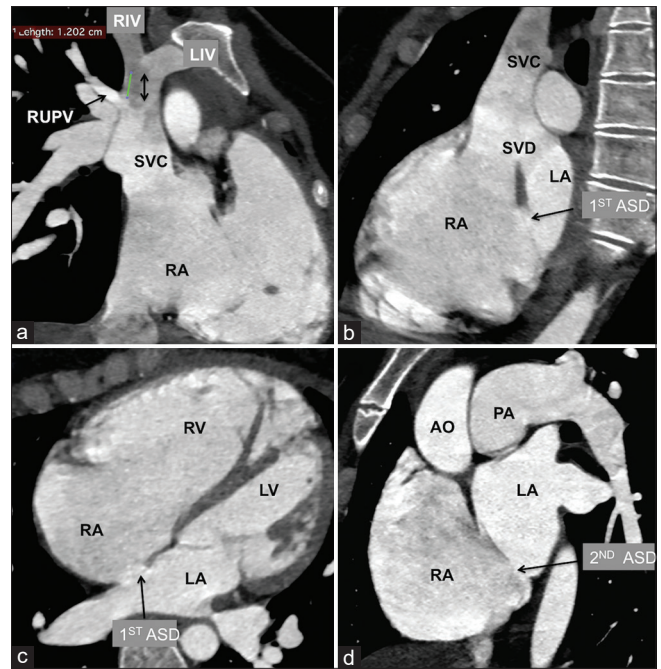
Computed tomographic modified coronal (a), sagittal (b), axial (c), and oblique (d) images demonstrate superior vena cava straddling of the sinus venous defect. The anchoring zone between the union of the right innominate veins and left innominate veins and the drainage of the right upper pulmonary vein is short, measuring 1.2 cm (double arrow). The right atrial and right ventricular dilation compared to the left atrium and left ventricle are additionally contributed by shunt through two atrial septal defects, one located in the middle of the oval fossa and other inferiorly. RUPV: Right upper pulmonary vein, LV: Left ventricle, RV: Right ventricle, LA: Left atrium, RA: Right atrium, SVC: Superior vena cava, LIV: Left innominate vein, RIV: Right innominate vein, SVD: Sinus venous defect, PA: Pulmonary artery, AO: Aorta, ASD: Atrial septal defect
